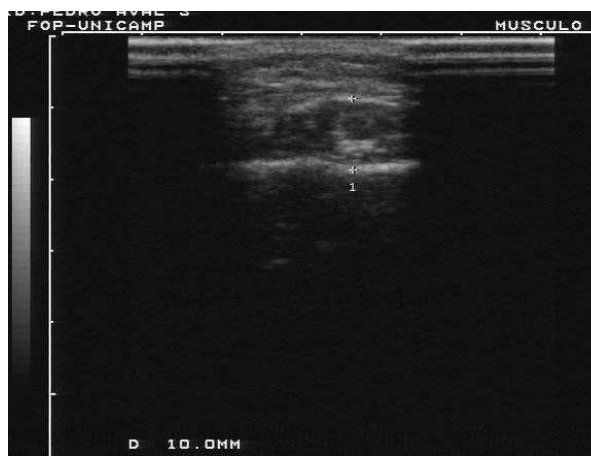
Caso clínico 1: imagem ultrasonográfica do músculo masseter (lado direito) em repouso (fase 3).
